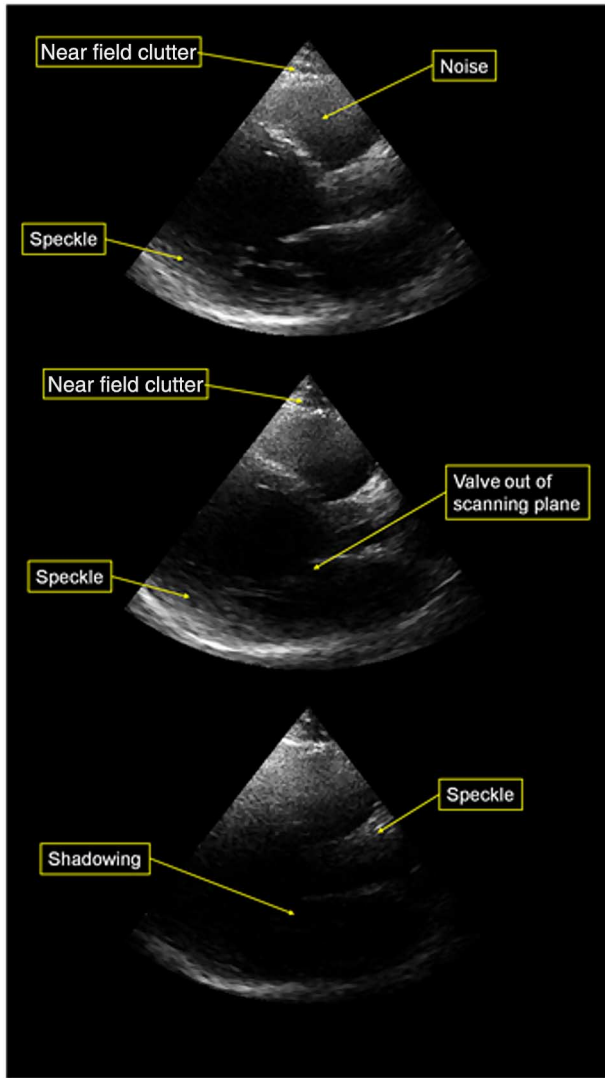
Examples of corrupted cardiac ultrasound data: near-field noise, clutter, shadowing, speckle, and structures moving out of the scanning plane.
